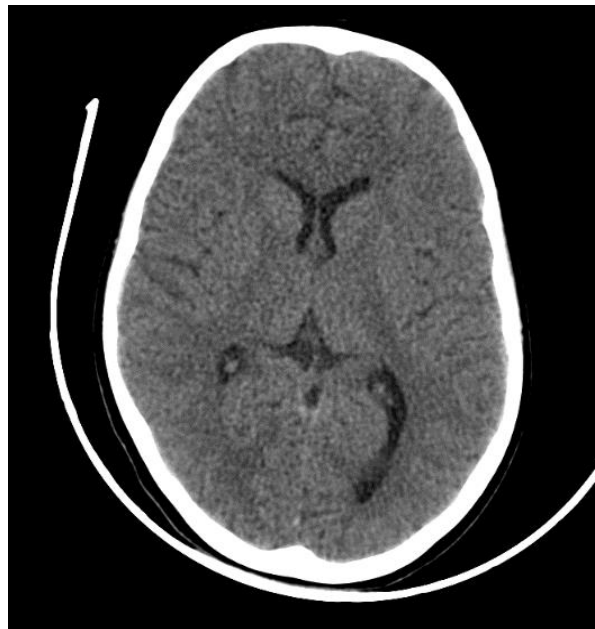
Contrast-enhanced brain CT scan performed to assess cerebral involvement shows no acute intracranial abnormalities, with preserved gray-white matter differentiation and symmetrical ventricles.
